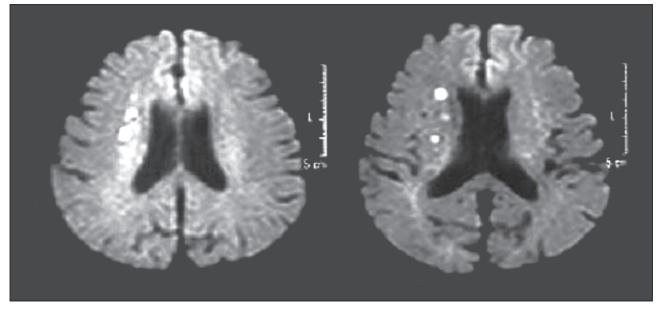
Diffusion-weighted magnetic resonance imaging shows multiple acute infarcts in chain form along the internal border zone region
